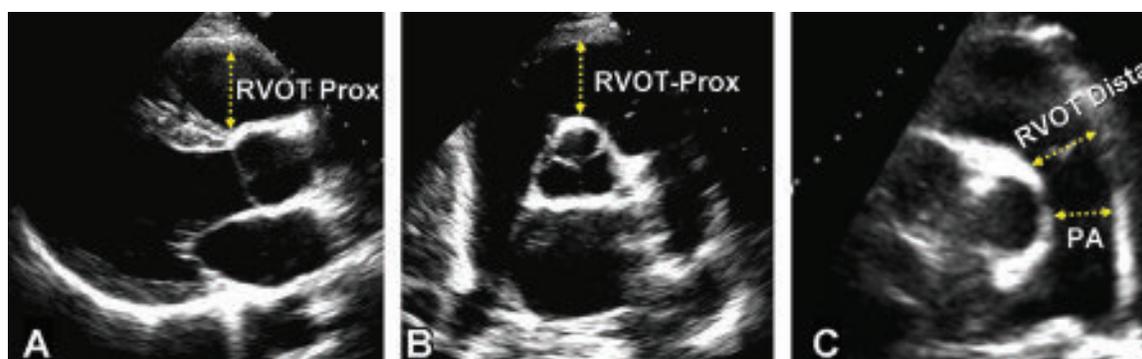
Measurement of RVOT dimension at the proximal or subvalvular level (RVOT-Prox) and at distal or pulmonic valve level (RVOT-distal) in the (A) parasternal long-axis RVOT anterior portion view, (B) basal parasternal short-axis view and (C) parasternal short-axis of pulmonary. Bifurcation view. PA indicates Pulmonary artery dimension between valve and bifurcation.
